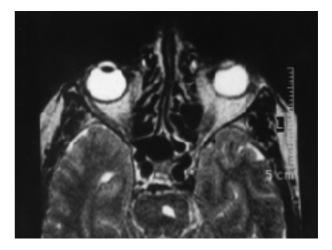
A-B. — Signal change due to an infarct in the left central part of the pons is seen as a well-defined hypointensity on the T1-weighted (A) and hyperintensity on the T2-weighted (B) MR images.
